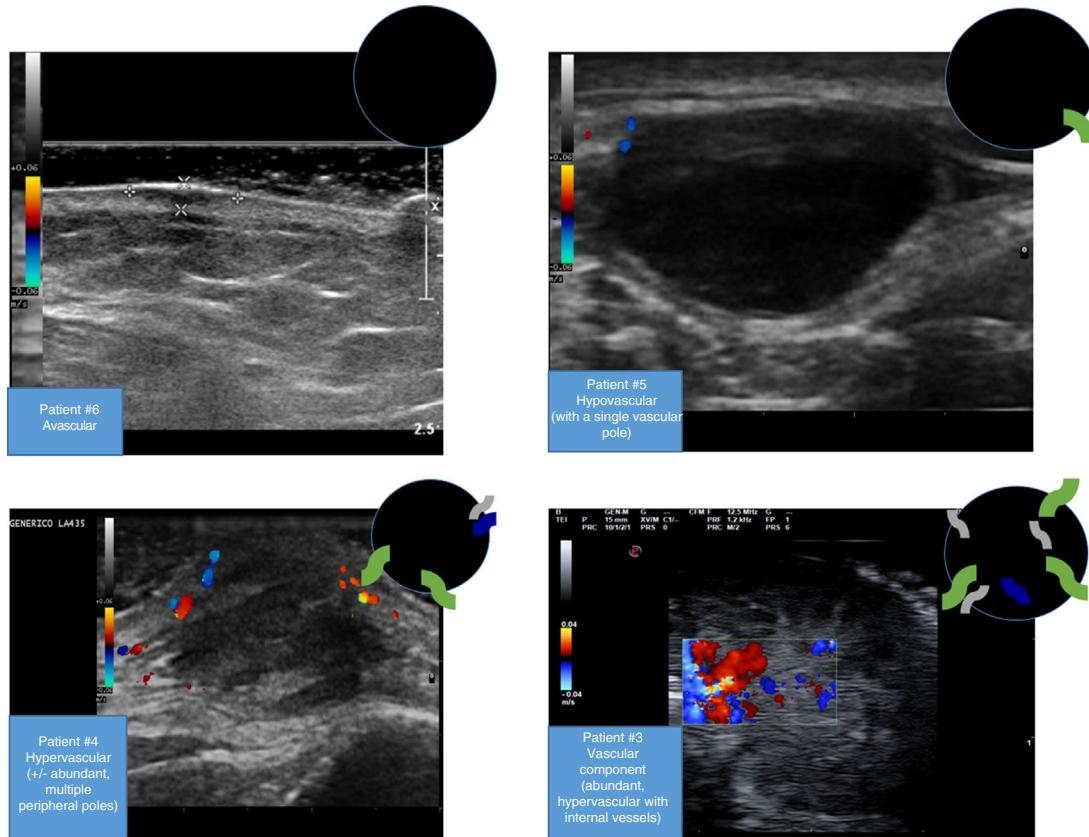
Doppler ultrasound patterns for patients in our series.
